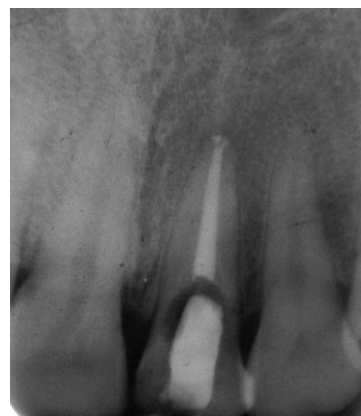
Post obturation IOPA Radiograph
